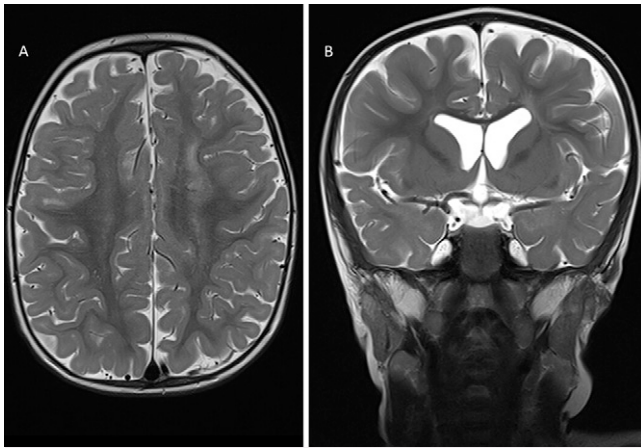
The patient's magnetic resonance imaging (MRI) of the brain, demonstrating periventricular leukomalacia. A: Axial T2-weighted image. B: Coronal T2-weighted image.
